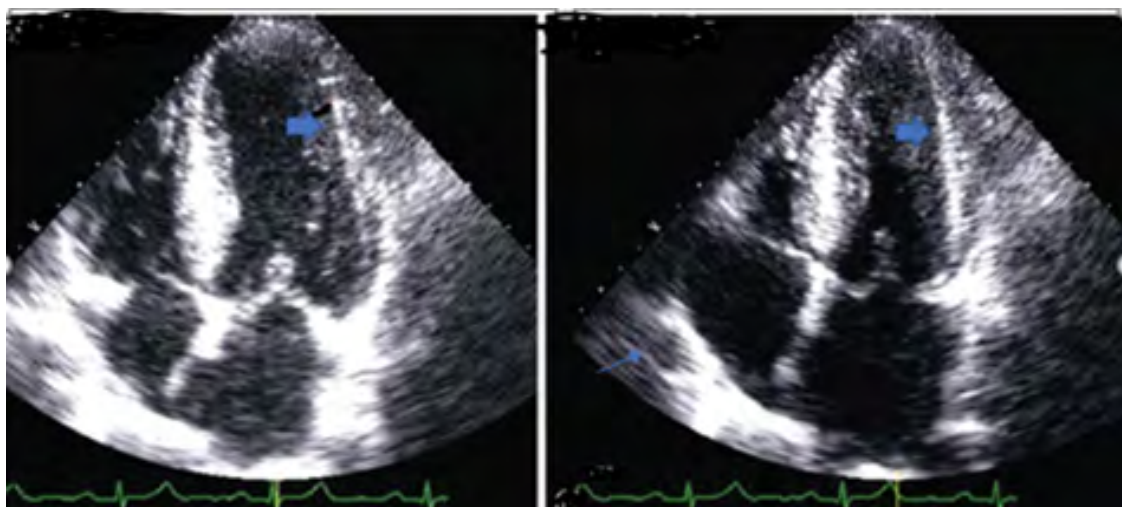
Four-chamber echocardiogram at the admission showed minimal lateral wall alterations (thick arrow) with mild pericardial effusion (thin arrow). Interventricular septum thickness 12 mm, left ventricular EF 64%, right ventricular EF 62%. Both atria were normal.
